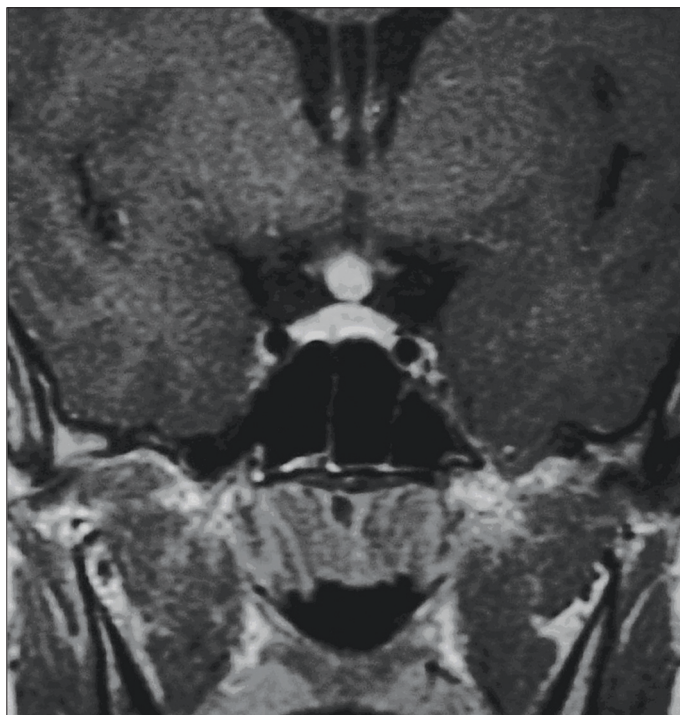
Coronal brain T1-weighted MR image after i.v. gadolinium demonstrates an enhanced mass of the pituitary and stalk.
